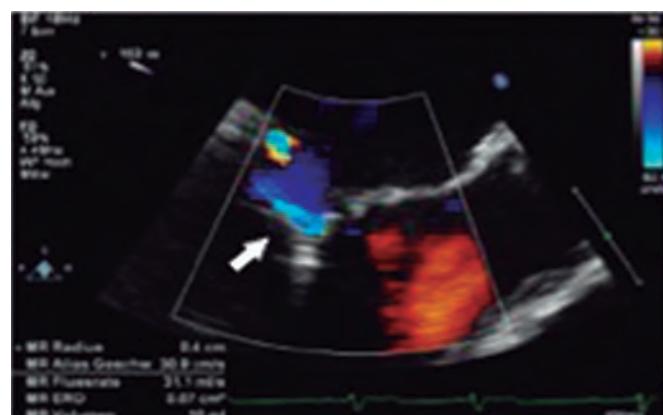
Two-dimensional transesophageal echocardiography image. Presence of acoustic shadowing due to clip implantation (arrow). Reproduced with permission from Lesevic et al.²¹
